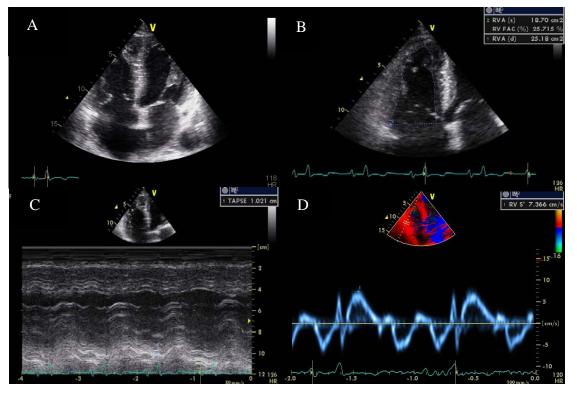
Evaluation of right heart systolic function by echocardiography. A. Dilated right atrium (RA) and right ventricle (RV), B. RV two-dimensional fractional area change (FAC) is 25.7cm/s, C. Tricuspid annular plane systolic excursion (TAPSE) is 1.02cm, D. Pulsed tissue Doppler velocities of RV free wall (RV S[']) is 7.37cm/s.
